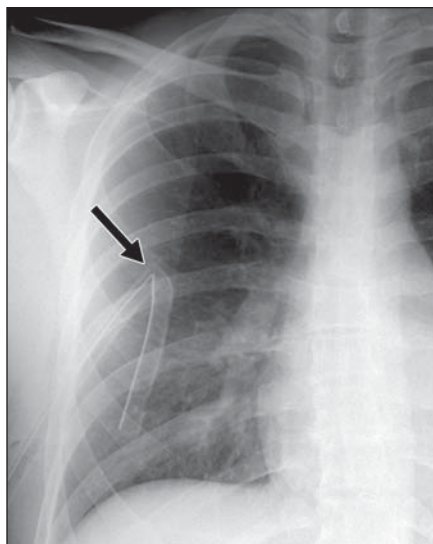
48-year-old man with chest tube kinking. Magnified posteroanterior chest radiograph performed after chest tube placement shows kinking of chest tube (*arrow*) precluding adequate pleural drainage.
